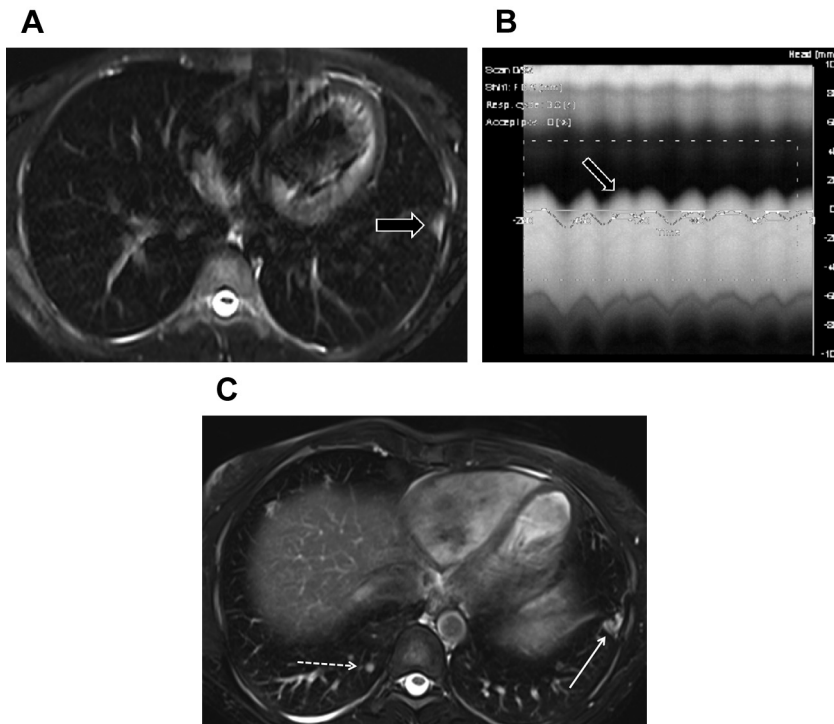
Navigator gating. (A) Axial T2 HASTE MR image shows pleural thickening (*arrow*) in the left lower lobe, but motion artifact degrades image quality. (B) The use of navigator gating improves image quality by only accepting signal acquired during the same phase in the respiratory cycle, typically end expiration. The diaphragmatic excursion is plotted (*arrow*) on a time axis. (C) The use of navigator gating can improve image quality, although it increases overall imaging time. The previously noted pleural thickening (*solid arrow*) in the left lower lobe is better visualized. A right lower lobe pulmonary artery (*dashed arrow*) clearly seen on this gated sequence was not evident on the nongated sequence.
